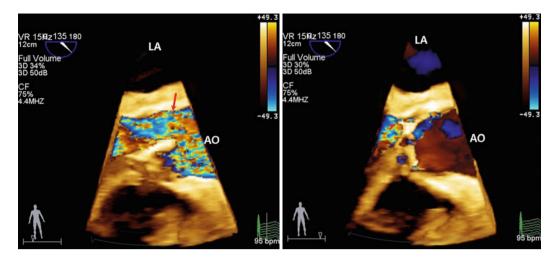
23 2D TEE color Doppler, long-axis view, showed aortic stenosis (*AS*) with high-velocity LV outflow in systole (*left*) and severe AR in diastole (*right*)
